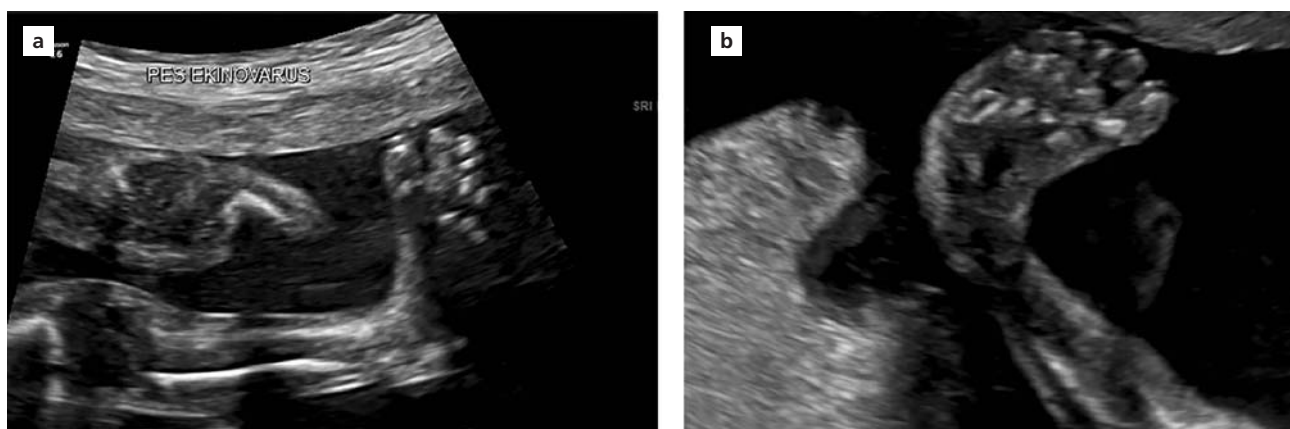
Gray-scale ultrasonography images (a and b) where tibia and fibula are on the same plane during ultrasonographic imaging of fetal foot on plantar level.
